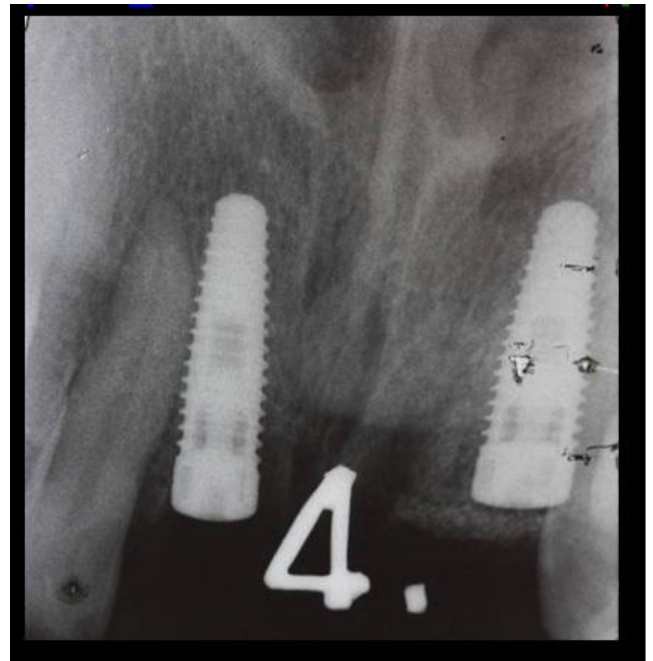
Peri-apical X-ray after first surgery
